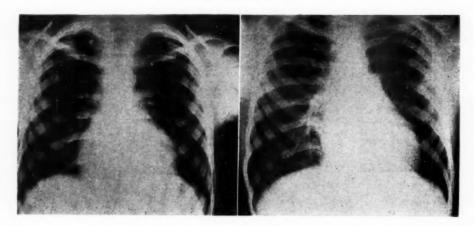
Chest x-ray films showing slight cardiac enlargement. A, May 18, 1943; B, May 8, 1947.
